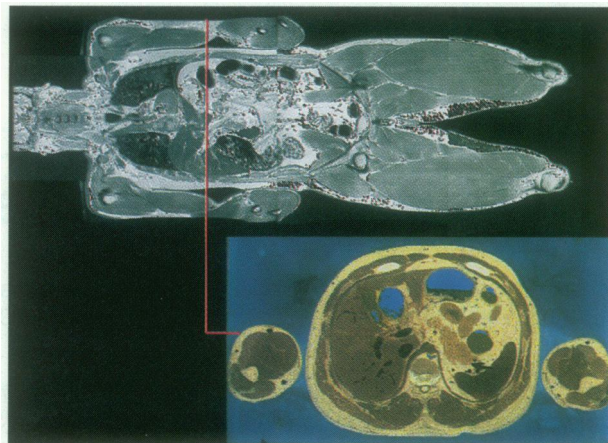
Sample images of the National Library of Medicine data set. (Top) Juxtaposition of longitudinal T2-weighted MRI. (Bottom) An axial photographic image.
